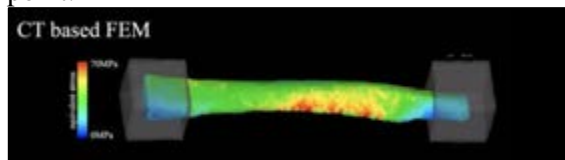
Measured bone strength by CT based FEA
